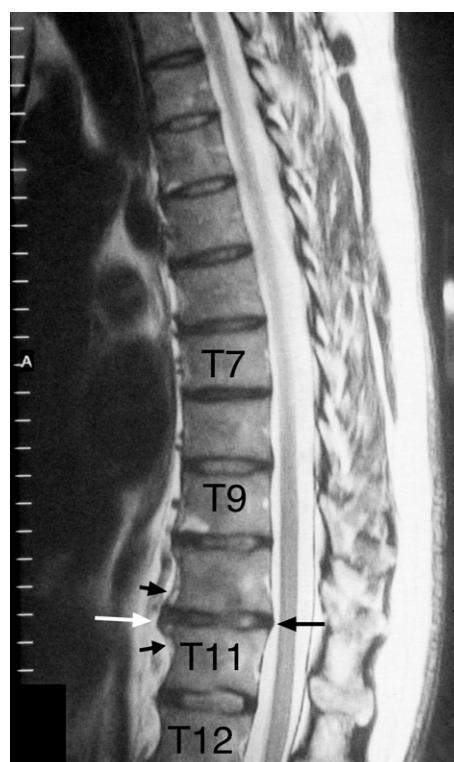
MRI thoracic spine sagittal T2-weighted image. Note the T10–11 intervertebral disc changes, i.e. (i) early desiccation, (ii) anterior disc protrusion (white arrows) that elevates the anterior longitudinal ligament (small black arrows), (iii) very small posterior disc bulge (long black arrow) that indents the pain-sensitive anterior surface of the dural tube, and (iv) early thinning of the disc.
